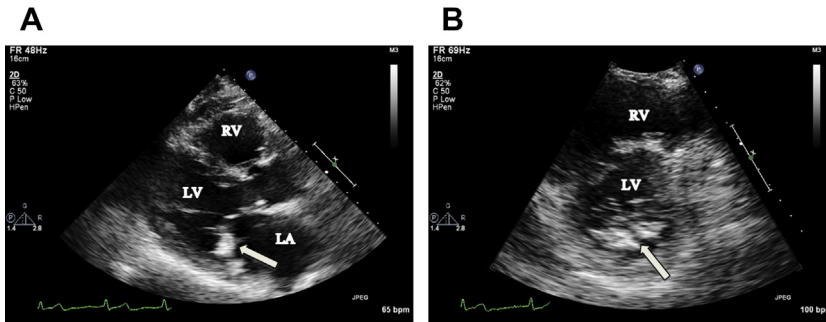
MAC. MAC is best appreciated in the parasternal long axis (A) and short axis (B) views as a bright echodensity along the posterior mitral annular plane (arrow). LA, left atrium; LV, left ventricle; RV, right ventricle.
